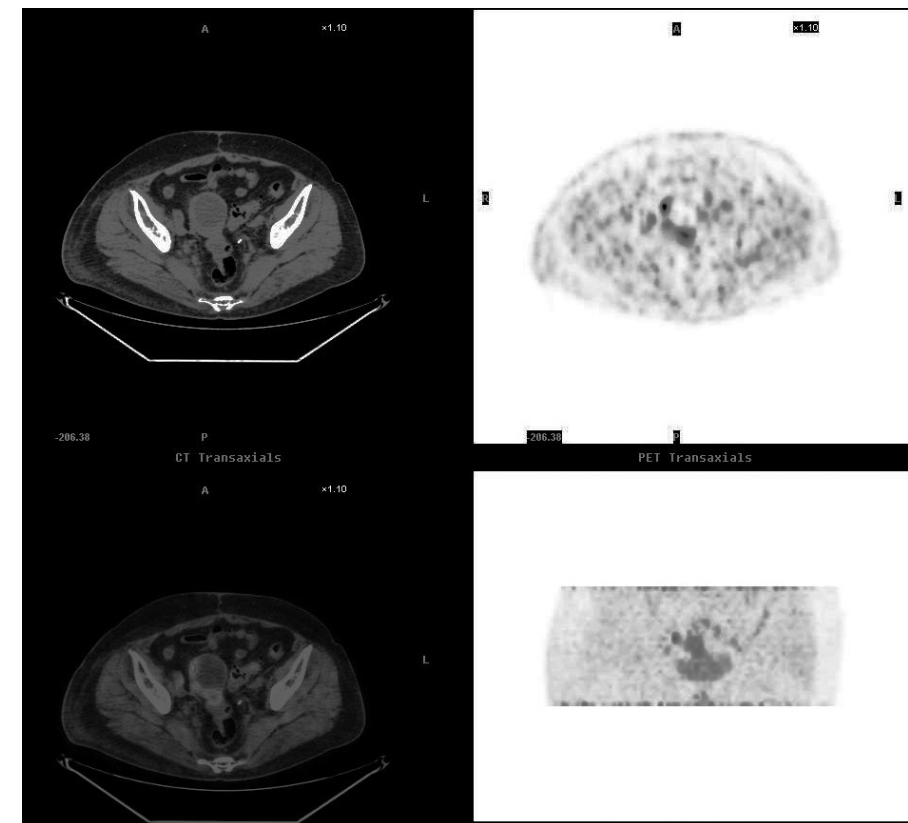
PET-CT integrative image showing a hypermetabolic lesion of the right uterine wall with a post-surgery diagnosis of endometrial adenocarcinoma
